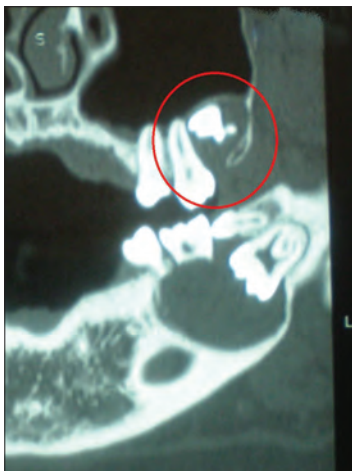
CT image shows maxillary radiolucent lesion surrounding the left impacted third molar
